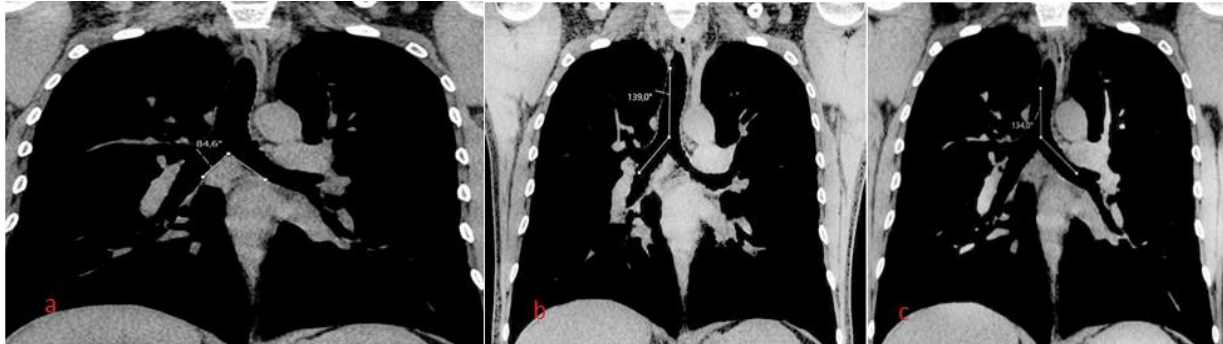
a-Left tracheobronchial angle measurement from CT images in coronal plane (Left main bronchus angle), b- Subcarinal angle measurement from CT images in the coronal plane, c- Right tracheobronchial angle measurement from CT images in coronal plane (Right main bronchus angle).
